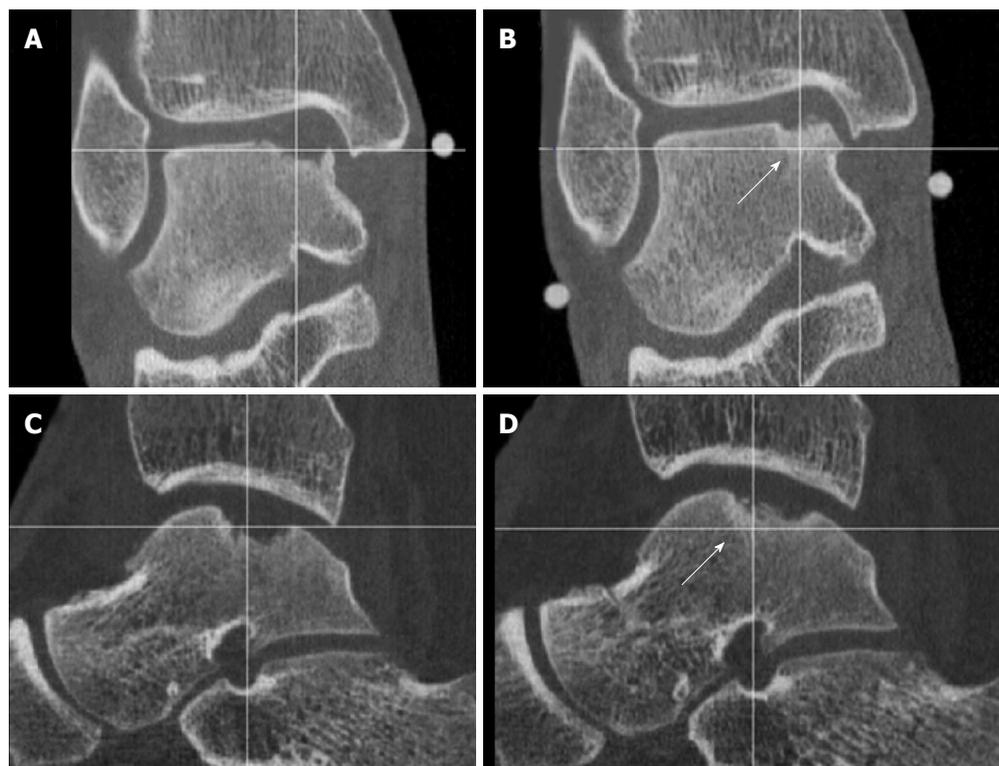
Coronal (A) and Sagittal (C) computed tomography-scans obtained 2 wk postoperatively, showing a medial osteochondral defect of the talus treated with arthroscopic debridement and microfracturing, these can be compared with 1-year postoperative computed tomography scans (B, D). Note the partial bony ingrowth of the defect.
